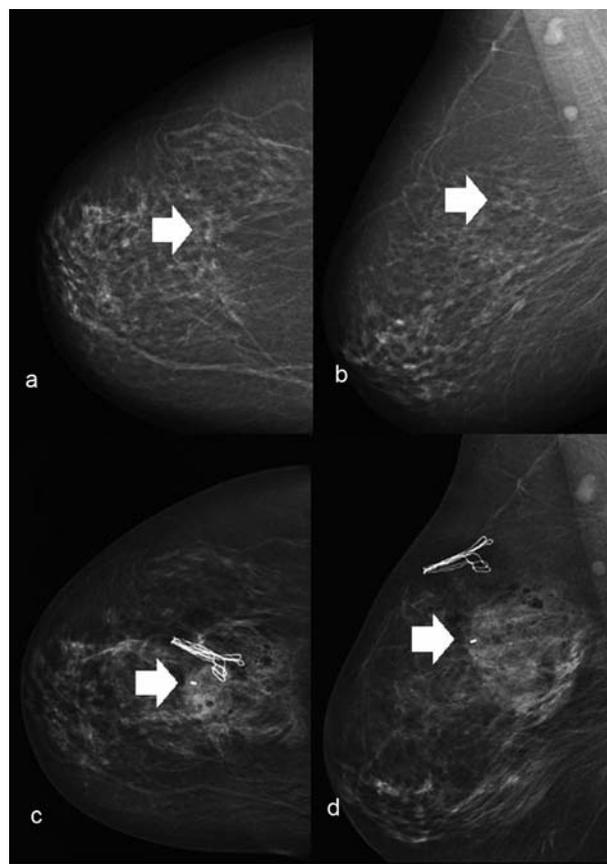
Example of a post-interventional hematoma on mammography. Despite the radiographically-visible hematoma the patient did not mention a clinically-visible hematoma as a complication. a and b show the craniocaudal (cc) and mediolateral (ml) view of the pre-interventional mammography, the location of the micro-calcifications are marked by an arrow. c and d show the craniocaudal (cc) and mediolateral (ml) view of the post-interventional mammography with diffuse intraparenchymal bleeding. The clip-marker is visualized at the location of the removed microcalcifications (arrow).
